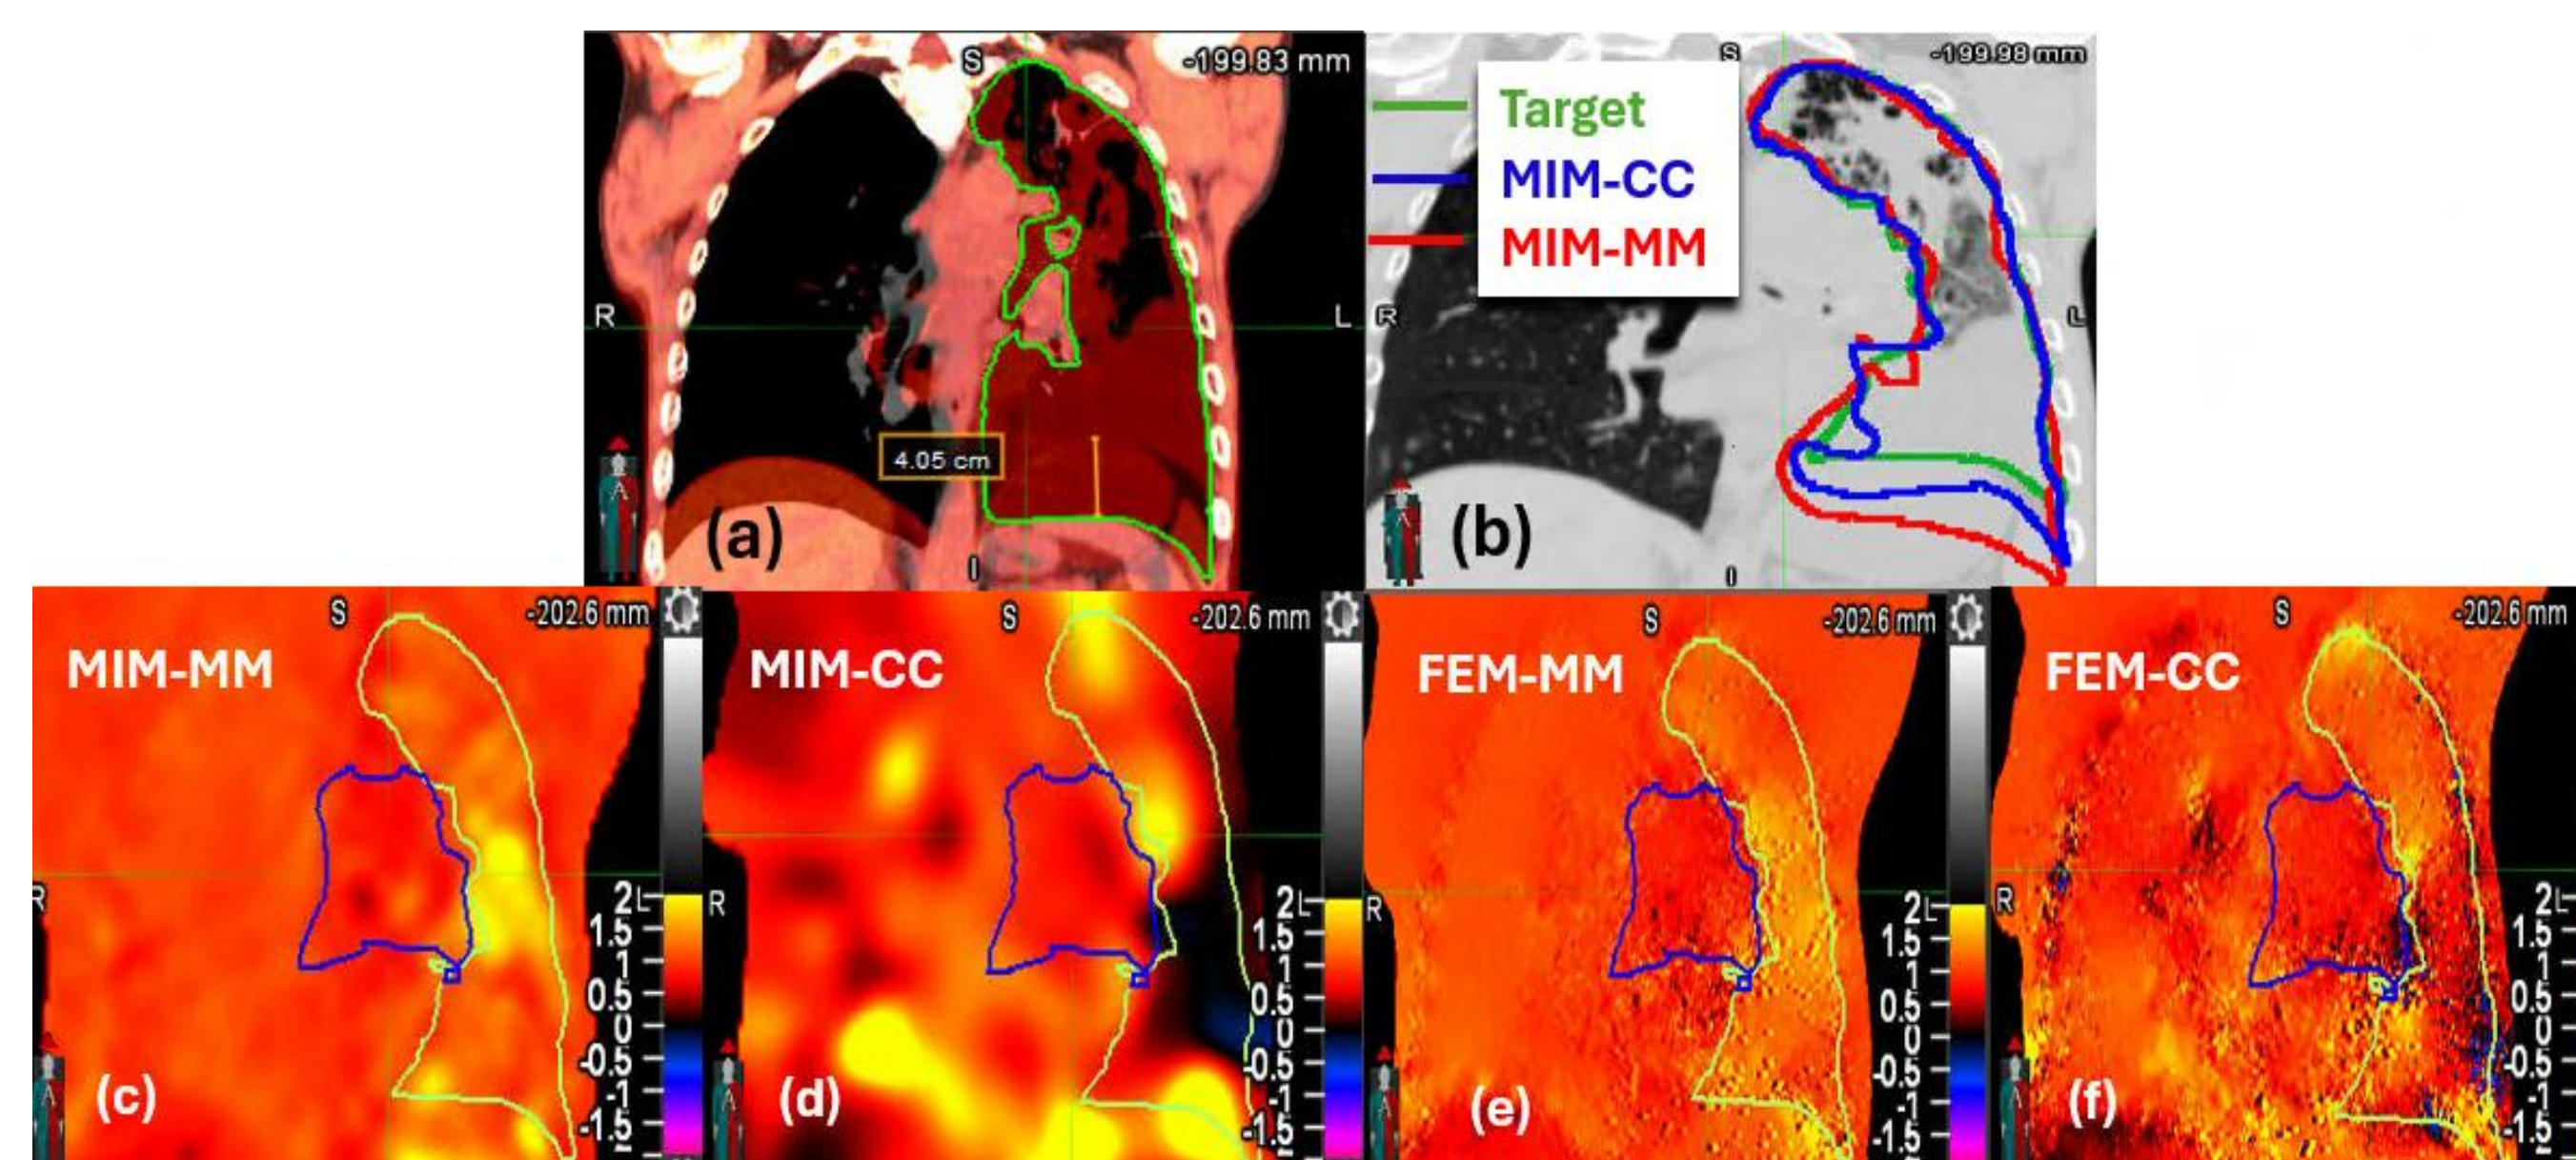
Coronal slices of the lung patient: (a) the initial planning CT rigidly registered to the replanning CT, (b) the initial planning CT overlaid with the contours deformed by the MIM-CC and MIM-MM algorithms; (c) and (d) Jacobian determinants of the MIM-MM and MIM-CC registrations; (e) and (f) Jacobian determinants of the FEM-MM and FEM-CC registrations.
